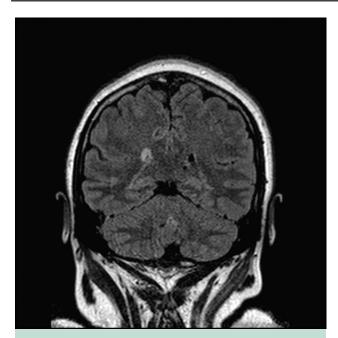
Magnetic resonance imaging of the brain reveals an area of hyperintensity abutting the right ventricle visualized on coronal fluid-attenuated inversion recovery image.
